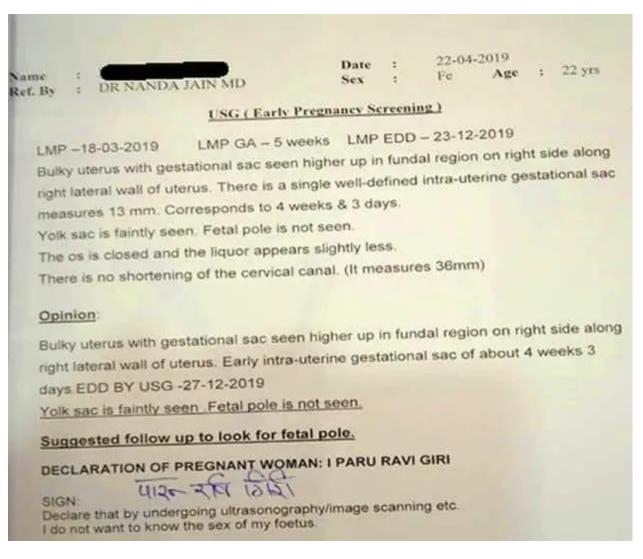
Ultrasonography findings before Homoeopathic treatment – Case-3
